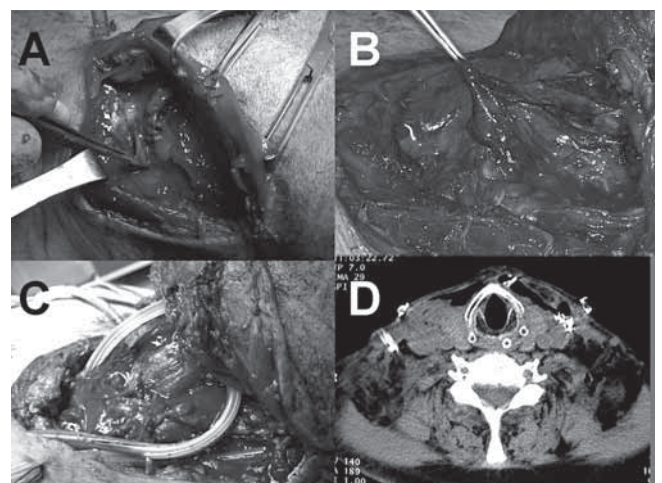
A: necrosis of the intermediate tendon of the omohyoid muscle; B: necrosis of the fascia overlying the infrahyoid muscles; C: neck field after debridement; D: postoperative CT scan showing no signs of residual infection.
